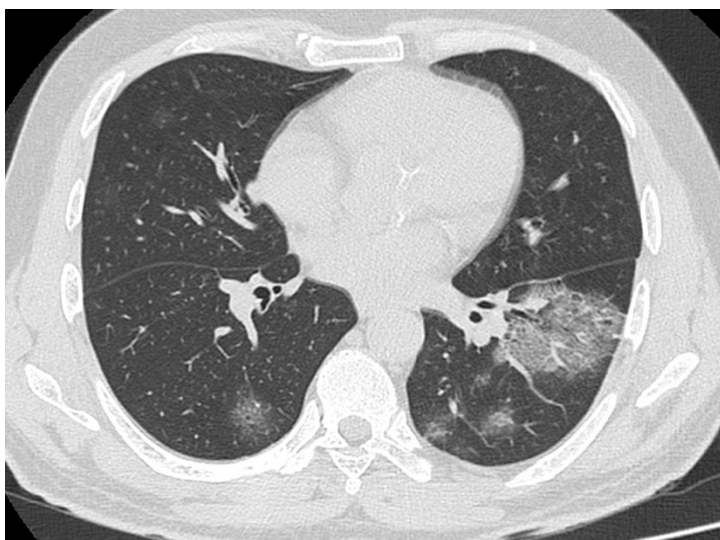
Axial HRCT chest image of a 35-year-old man with COVID-19 shows patchy ground glass opacities in both lungs with a large area of ground glass opacity in the left lower lobe associated with septal thickening giving a crazy paving appearance.
